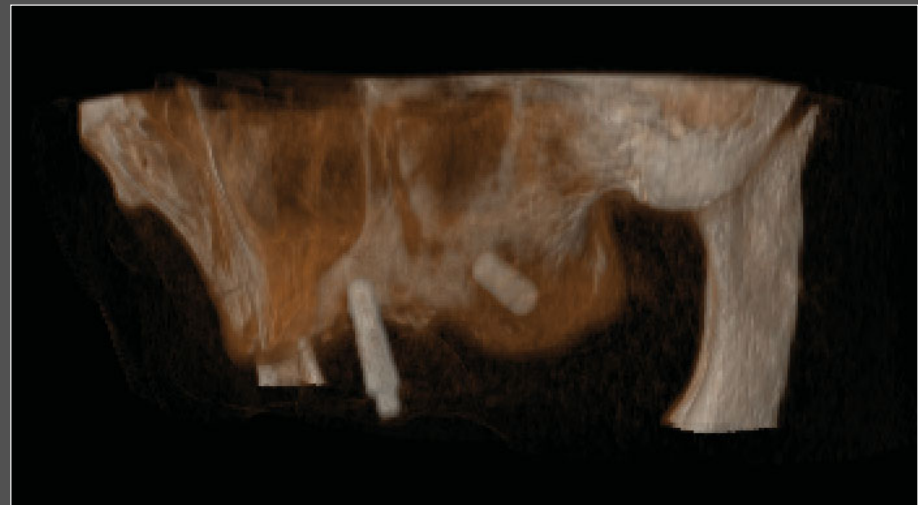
3D Reconstruction of CT scan
